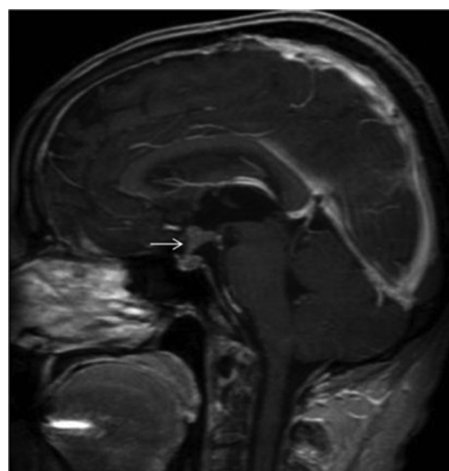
Sagittal contrast-enhanced T1-weighted MR image shows the infiltration and enlargement of the hypophyseal infundibular stalk (arrow).
